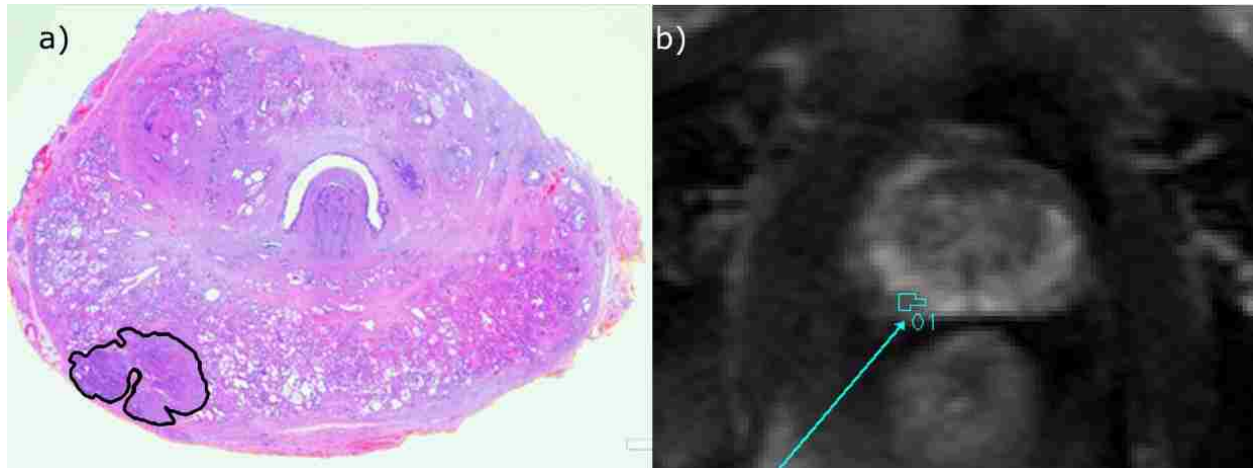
The pathologic slide created by the uropathologist (a) and the corresponding ROI drawn in the CEST-MR image (b).
